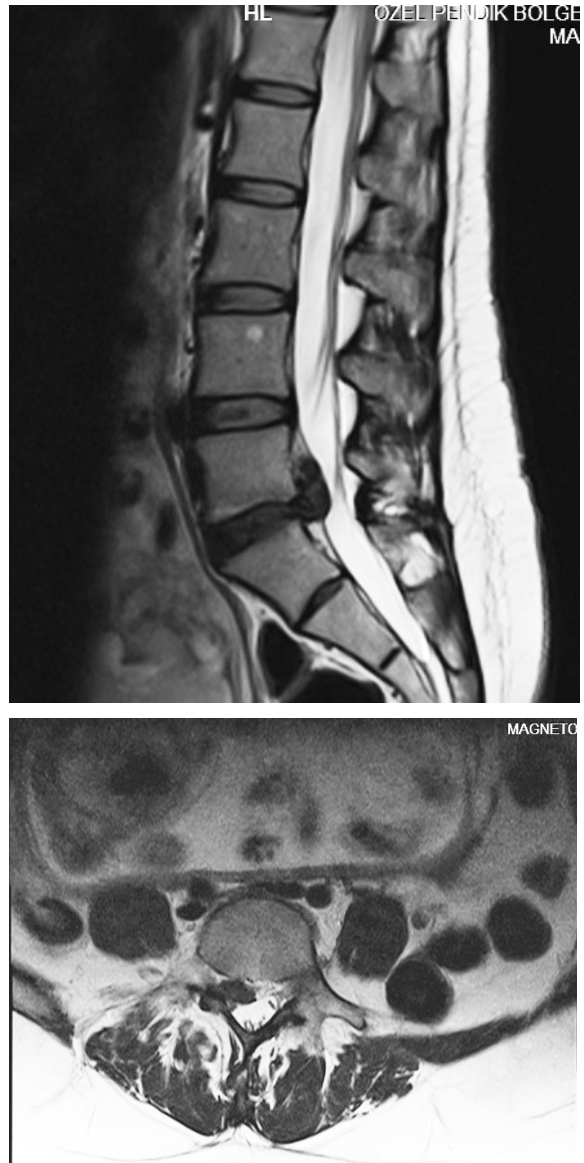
Case 2.1, 2 Lumbar MR images preoperatively.
